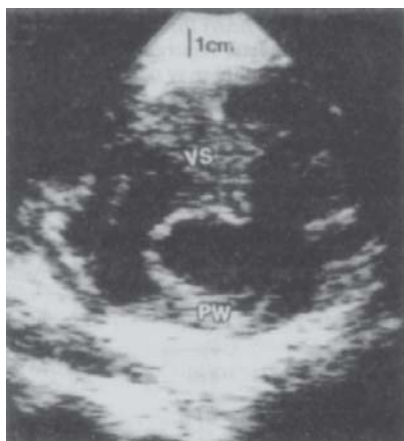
Hypertrophic cardiomyopathy* Note the asymmetrical septal hypertrophy in the echocardiography.
